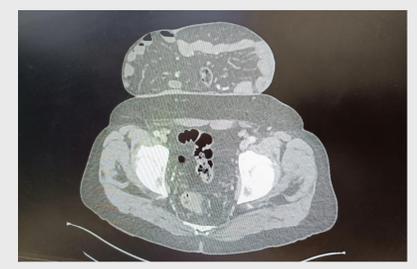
CT: Anatomical location: inferior border 12.2cm from pubic symphysis, superior border 21.5cm from xiphisternum (Sac content: most of the small bowel)
